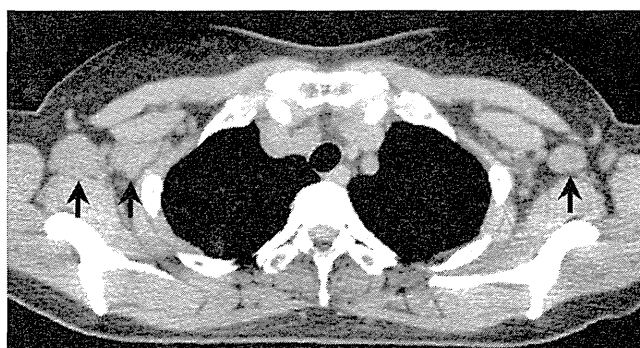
Acute transformation (acute type) in a 43-year-old female patient with chronic type ATLL, 14 days after the onset of general fatigue and lymph node enlargement of the neck and axillary regions. Transverse CT image (1-mm thickness) at the level of the axillary regions shows multiple axillary lymph node enlargement (*arrows*)
